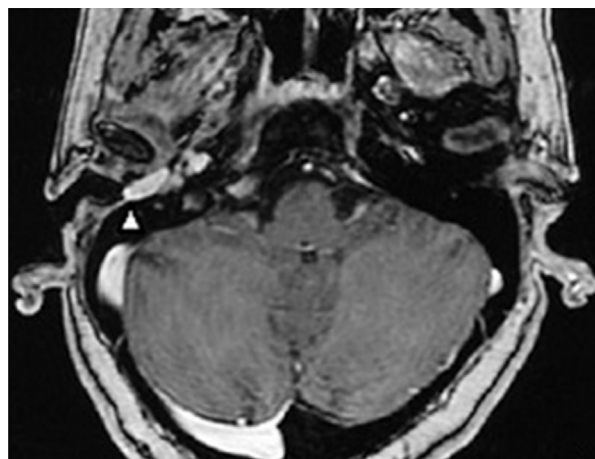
Postoperative MRI of the right temporal bone with contrast demonstrating the aural polyp remnant (arrow head).
